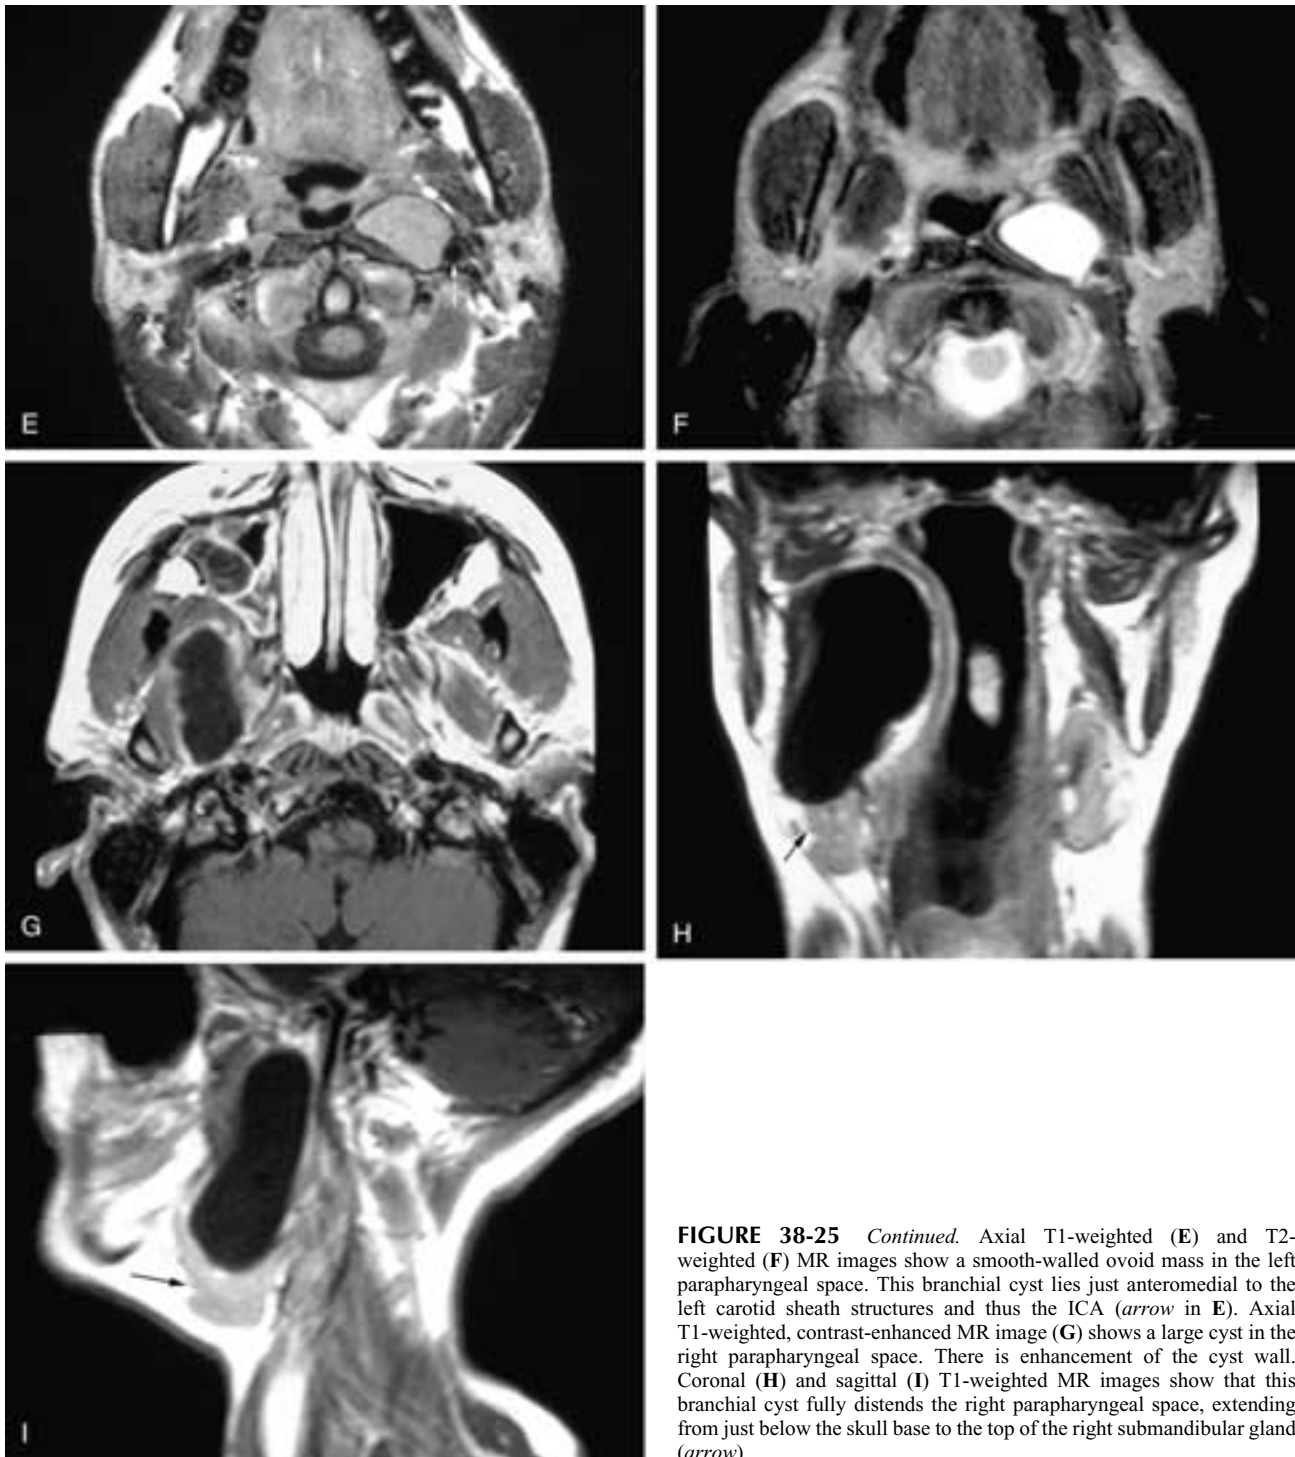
Continued.* Axial T1-weighted (E) and T2-weighted (F) MR images show a smooth-walled ovoid mass in the left parapharyngeal space. This branchial cyst lies just anteromedial to the left carotid sheath structures and thus the ICA (arrow in E). Axial T1-weighted, contrast-enhanced MR image (G) shows a large cyst in the right parapharyngeal space. There is enhancement of the cyst wall. Coronal (H) and sagittal (I) T1-weighted MR images show that this branchial cyst fully distends the right parapharyngeal space, extending from just below the skull base to the top of the right submandibular gland (arrow).
